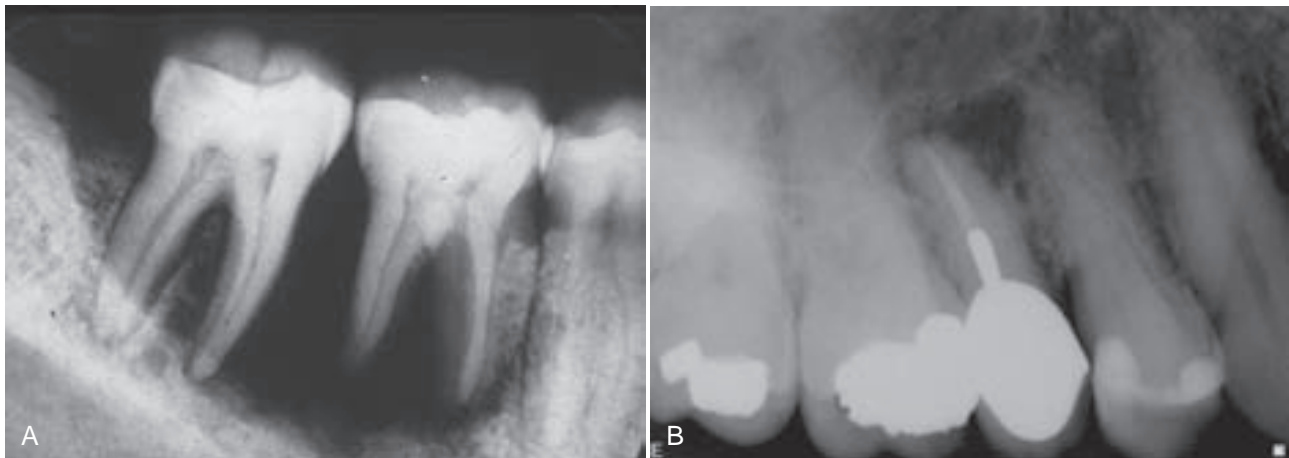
Langerhans cell histiocytosis. A, Focal severe bone loss and radiolucency giving the impression of floating teeth. B, Nondescript periapical radiolucency. (Courtesy of Dr. Carlene Tsai, private practice, Salem, Mass.)
